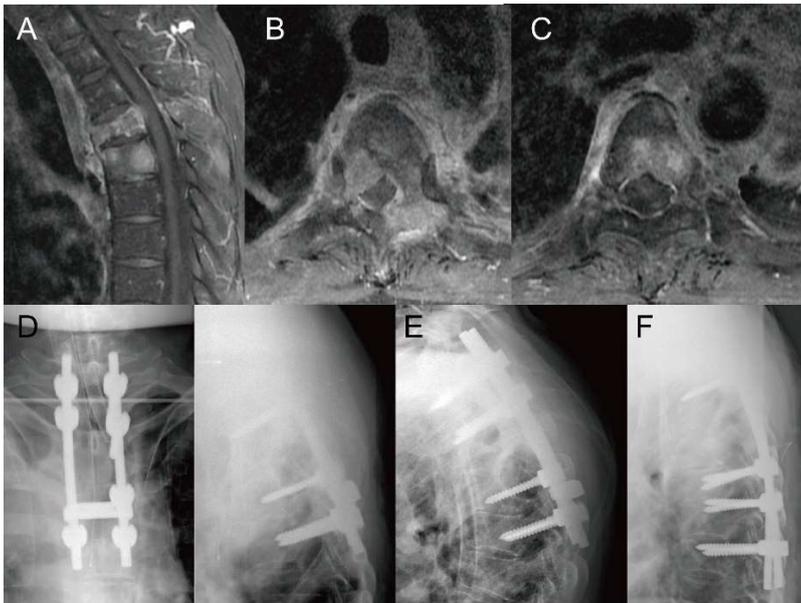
A descriptive case of instrumentation failure following a laminectomy-only surgery: A 52-year old male with a spinal metastasis of non-small cell lung cancer. (A) Preoperative sagittal MRI shows pathologic fracture and spinal cord compression at the T4 level. In the axial MRI, (B) the anterior and posterior components are involved at the T4 level, and (C) the anterior (left side) component is involved with metastasis at the T5 level. (D) The patient underwent a posterior laminectomy and stabilization from T2 to T6. (E) Two months after the initial surgery, pedicle screws at the T5–6 level had pulled out. The patient received postoperative radiotherapy at the T4–5 level after the surgery. (F) Revision surgery was performed, and the posterior instrumentation was extended distally to the T7 level.
